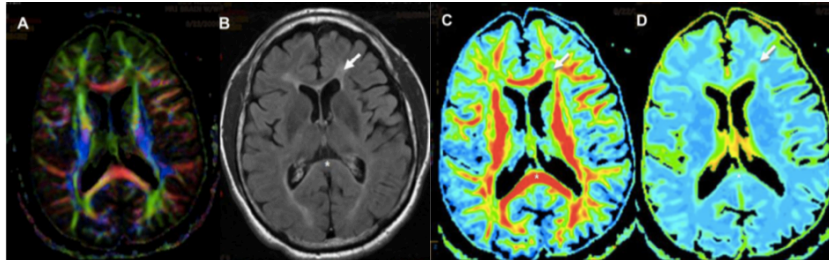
Findings of DTI in multiple sclerosis lesions. A. FA color-coded map. B. Fluid-attenuated inversion recovery (FLAIR). C. FA map. D. MD map (39).
